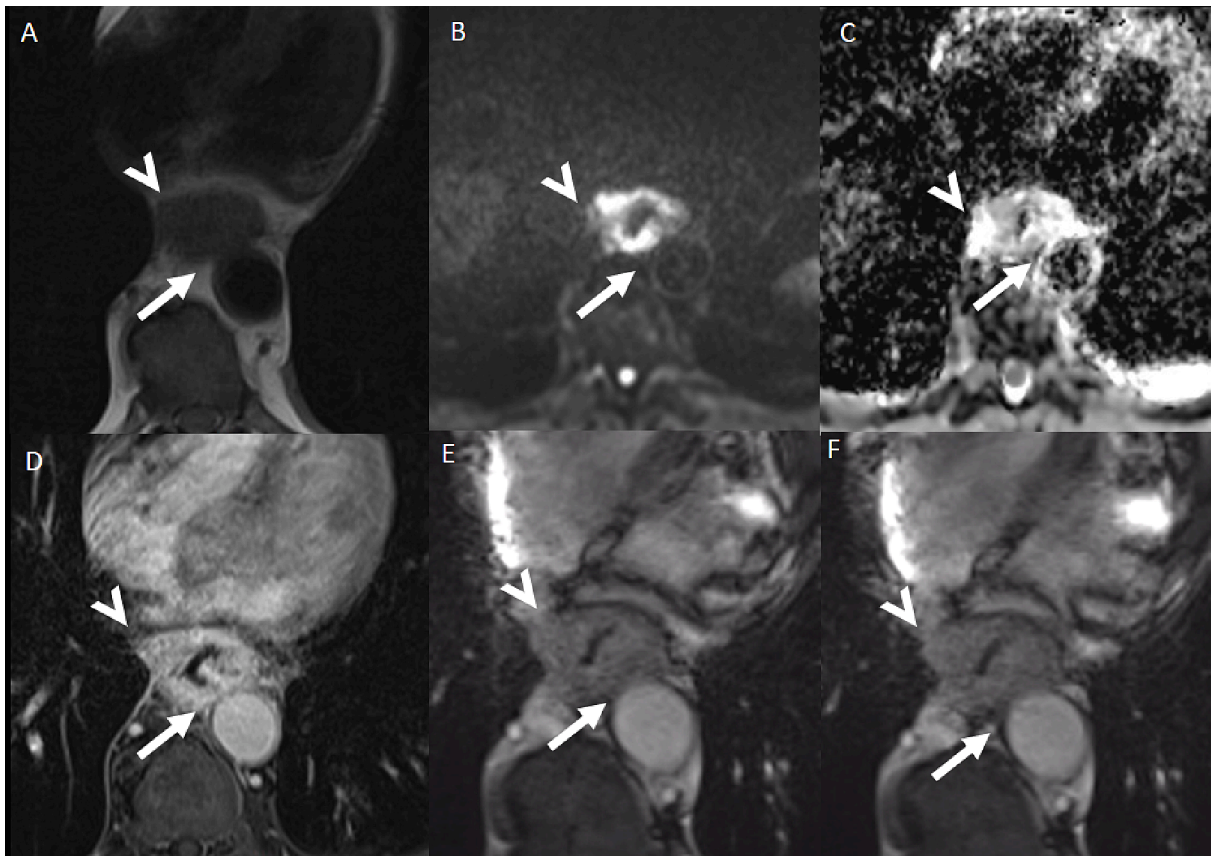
70 y.o. men with adenocarcinoma of middle third of the esophagus. On static sequences with T2-wi Blade (A), DWI and corresponding ADC map (B and C), T1-wi VIBE Dixon at 90 s after contrast injection (D), there is a close contact between the esophagus lesion and aortic wall (arrows) as well as the right pleura (arrowheads). On cine sequences (E and F, transverse SSFP two timepoints - complete video on web supplementary data [Movie 6](#)), the lesion and the aortic wall have a close contact, without mobility between each other, compatible with a T4b lesion, like the reference standard staging. Abbreviations: *wi*: weighted imaging; *VIBE* DWI: Diffusion weighted imaging; *ADC*: Apparent diffusion coefficient; *SSFP*: steady state free precession.
